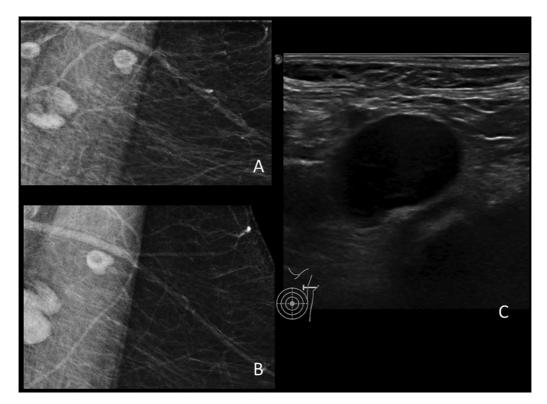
Mammograms from 2015 (A) and 2018 (B). Changes in the lymph node cannot be appreciated if the image is technically inadequate and the periphery of the mammogram is not scrutinized. This lady presented 18 months after a screening mammogram with left axillary mass as seen on ultrasound (C), category 2 interval cancer.
